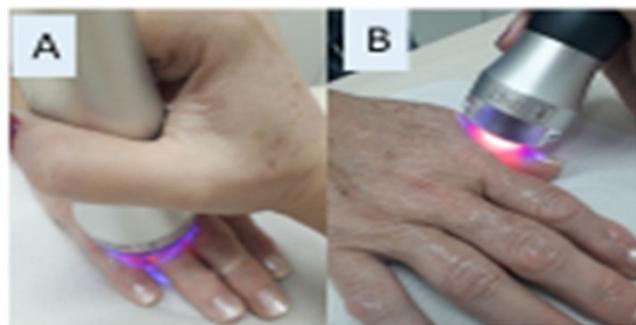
Application of combined laser and ultrasound therapy without the tub. In A application of conjugate therapy, in the dorsal aspects of the proximal interphalangeal joint of the fourth finger. In B application of conjugate therapy in the interphalangeal joint of the first finger.
